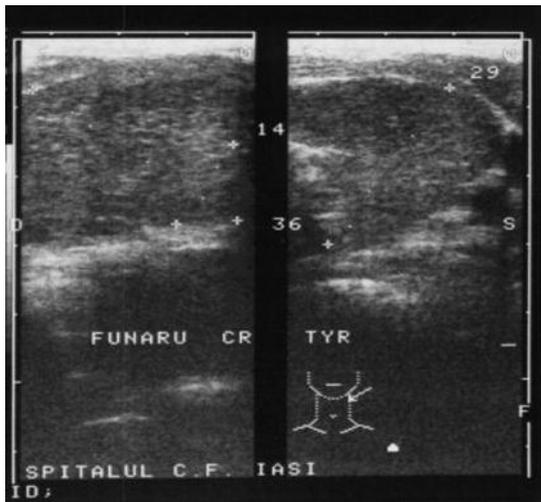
Ultrasonography: diffuse, hypoechoic thyroid gland (FC, 12 yrs)
